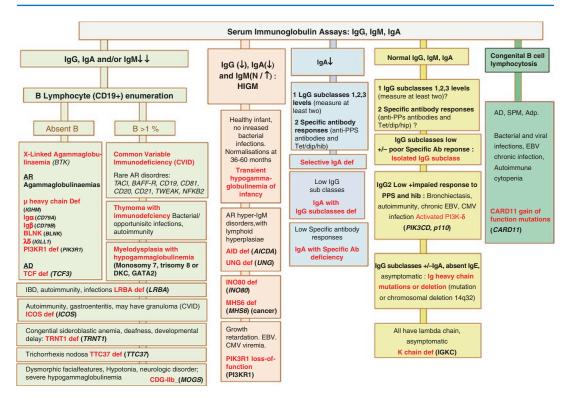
Modified IUIS phenotypic classification of predominantly antibody deficiencies [47]. *Ab* antibody, *Adp* adenopathy, *Anti PPS* anti- pneumococcus antibody, *AR* autosomal recessive, *CD* cluster of differentiation, *CDG-IIb* congenital disorder of glycosylation, type IIb, *CMV* cytomegalovirus, *CT* computed tomography, *EBV*
